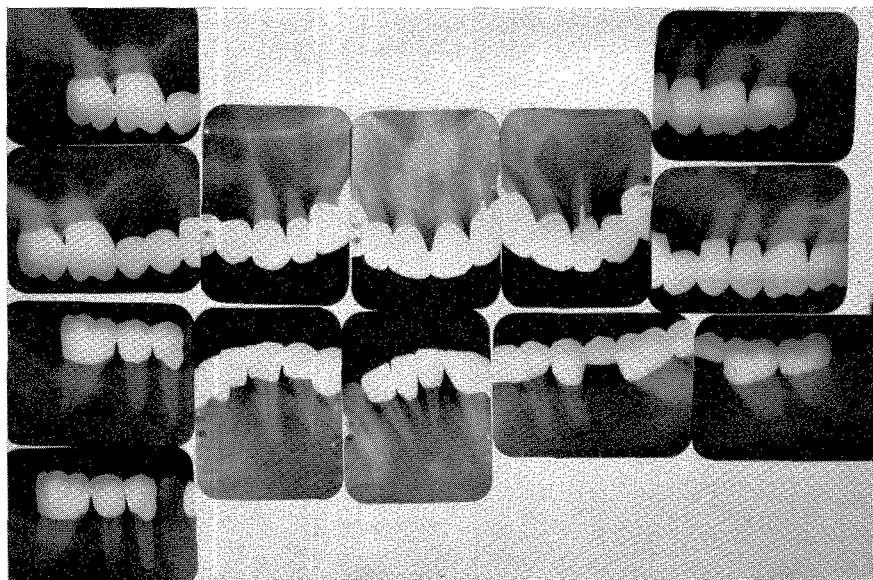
Roentgenograms of the completed work taken in January, 1953.
